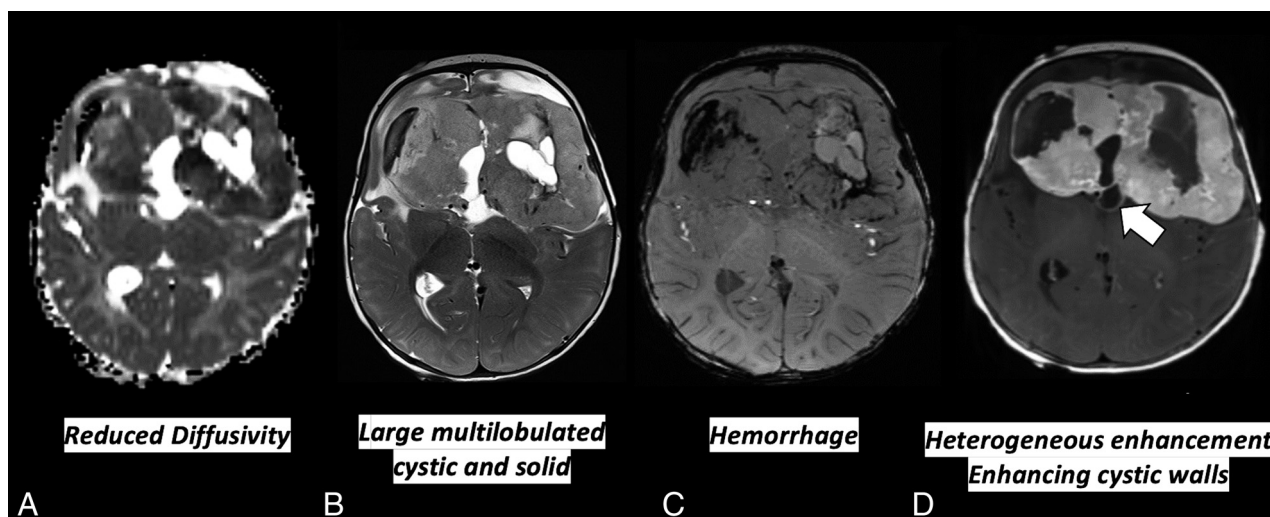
Nine-month-old with infantile hemispheric glioma, *RTK1* fusion positive. ADC map, T2-weighted, SWI, and T1-weighted postcontrast axial images of the brain show a large solid and cystic bifrontal mass with strong decreased diffusivity compared with adjacent cortex, hemorrhage, and enhancement. Note the enhancing cystic walls (white arrow).
